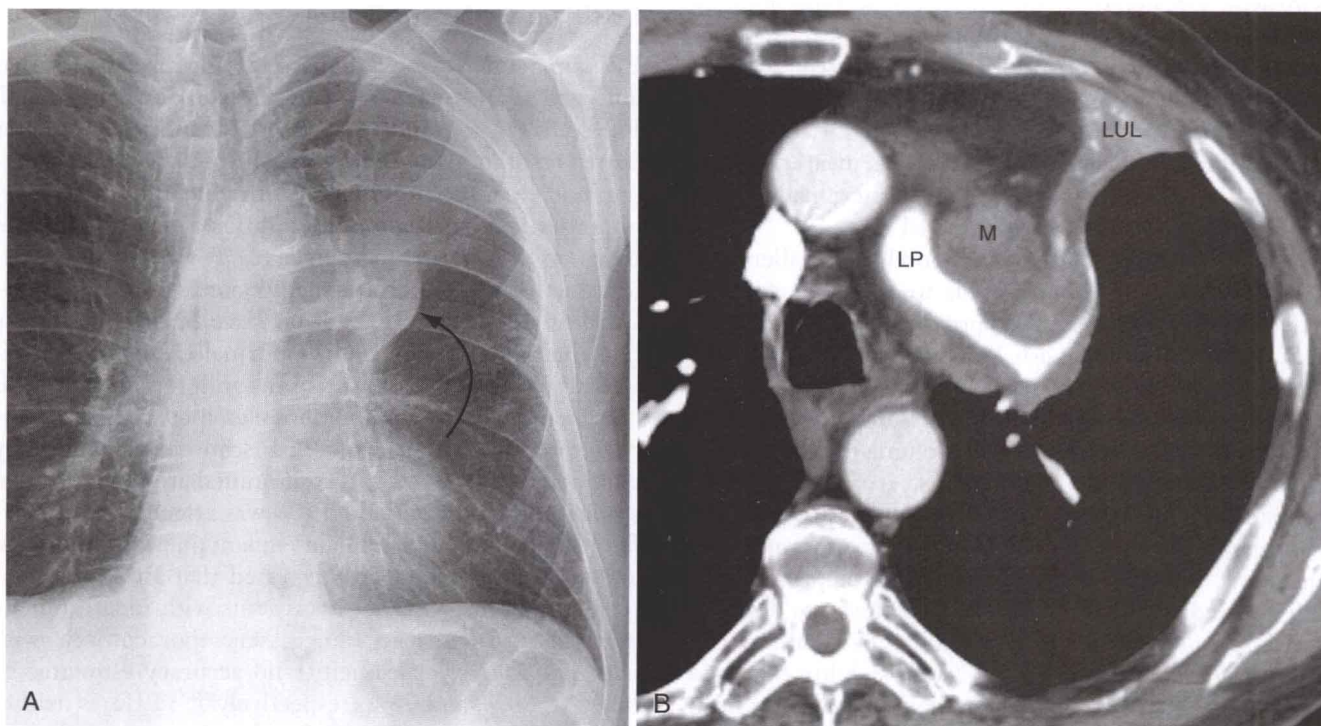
Newly diagnosed poorly differentiated squamous cell lung cancer in a 71-year-old man. A, Chest radiograph at presentation shows a central left hilar mass (arrow). The hazy opacity above the arrow represents the collapsed left upper lobe. B, Contrast-enhanced chest CT scan at the level of the left pulmonary artery (LP) shows the central mass (M) encasing and narrowing the left pulmonary artery, causing left upper lobe (LUL) collapse.
